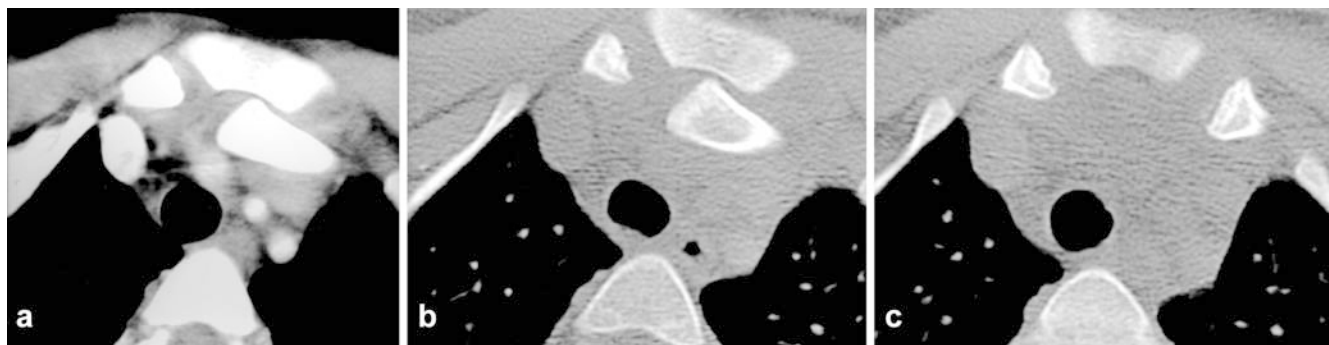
Left posterior sternoclavicular dislocation. Axial contrast-enhanced CT scan through sternoclavicular region shows posterior and medial dislocation of clavicle behind upper sternum area; note reduced upper anterior mediastinal space causing dysphagia but no vascular compromise (a soft tissue window setting, b bone window setting). c Normalized sternoclavicular relationship after reduction; thin lamellar metaphyseal fragment indicates metaphyseal type 2 Salter lesion, not appreciated before open reduction. (T.H., 15-year-old girl)
